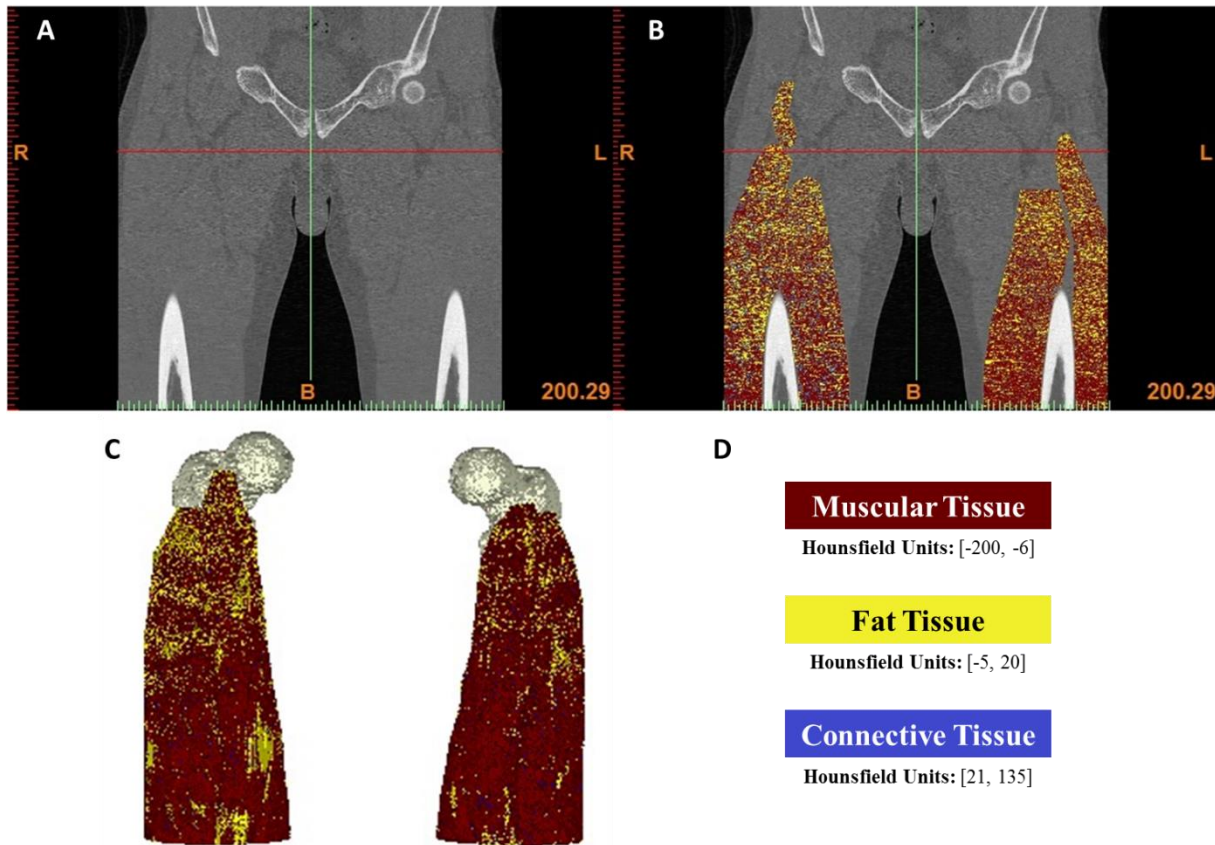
Representative subject’s CT scanning region, showing A) a CT slice in a coronal view showing the quadriceps muscles, B) the same slice after segmentation of the quadriceps muscles, and C) the quadriceps muscles and the femur in a 3D view after segmentation. D) Legend showing Hounsfield unit values and respective tissue coloring: muscles are labeled red, fat is yellow, and connective tissue is blue (none visible from this view) [347].
